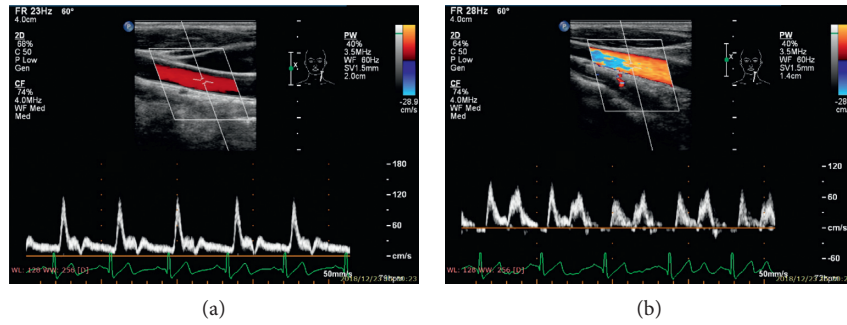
Blood flow velocity and spectrum measurement based on Color Doppler Ultrasound. (a) pre-EECP intervention. (b) During EECp intervention. Note that EECp significantly changed the blood flow pattern and increased the blood flow level in diastole.
